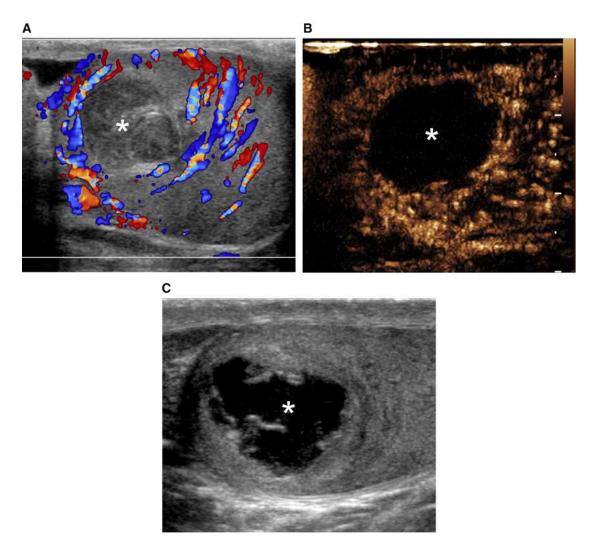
Spontaneous intratesticular hematoma in a patient presenting with abrupt onset of severe left testicular pain and swelling and no history of trauma. A Color Doppler ultrasonography reveals a hypoechoic avascular lesion (asterisk). B CEUS
